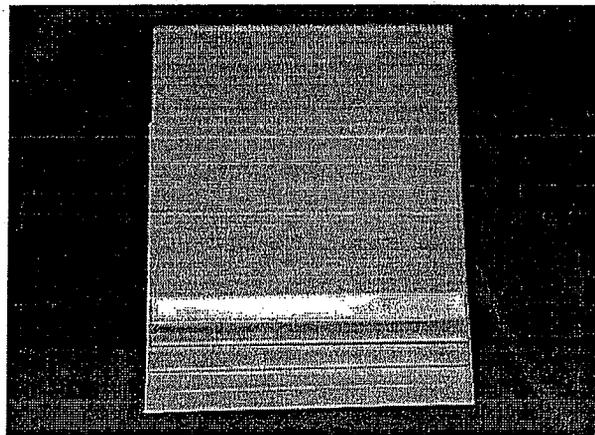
An aluminum stepwedge, which may be purchased or fabricated, can aid in the quality assessment of a radiographic film processor.
